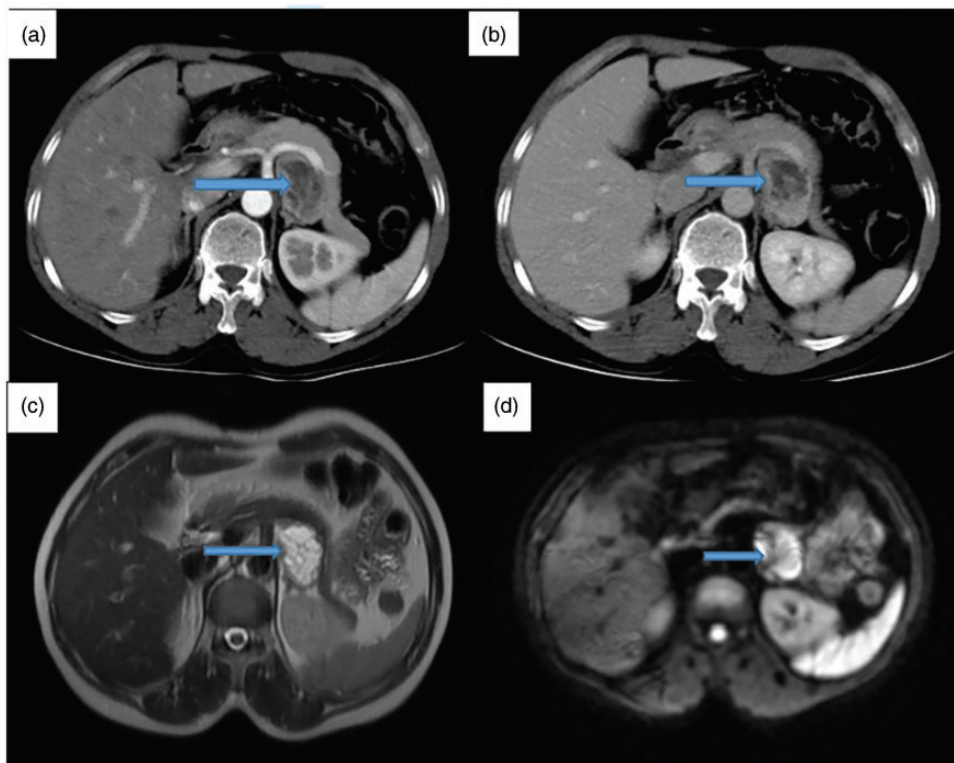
Computed tomography (CT) and magnetic resonance image (MRI) of the tumour: (a) From the CT image, the mass (blue arrow) showed obvious inhomogeneous enhancement in the enhanced arterial phase, (b) From the CT image the mass (blue arrow) showed continuous enhancement in the portal vein stage, (c) An oval, cystic, solid mass (blue arrow) with equal T2 signal in wall and septum, with multiple long T2 hyperintense cystic changes was shown on MRI and (d) The diffusion weighted imaging (Dwl) sequence of the mass (blue arrow) showed a strong signal.
